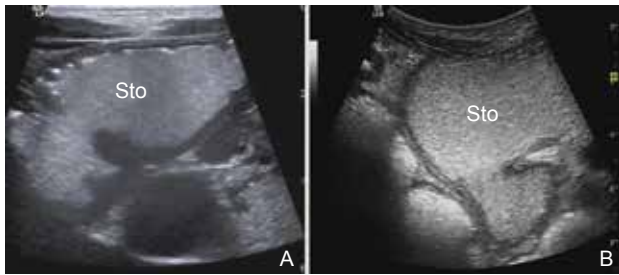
Contrast ultrasound imaging shown gastritis. (A) Acute gastritis (lesser curvature of gastric body); (B) Chronic gastritis (gastric angle). Sto, stomach.
